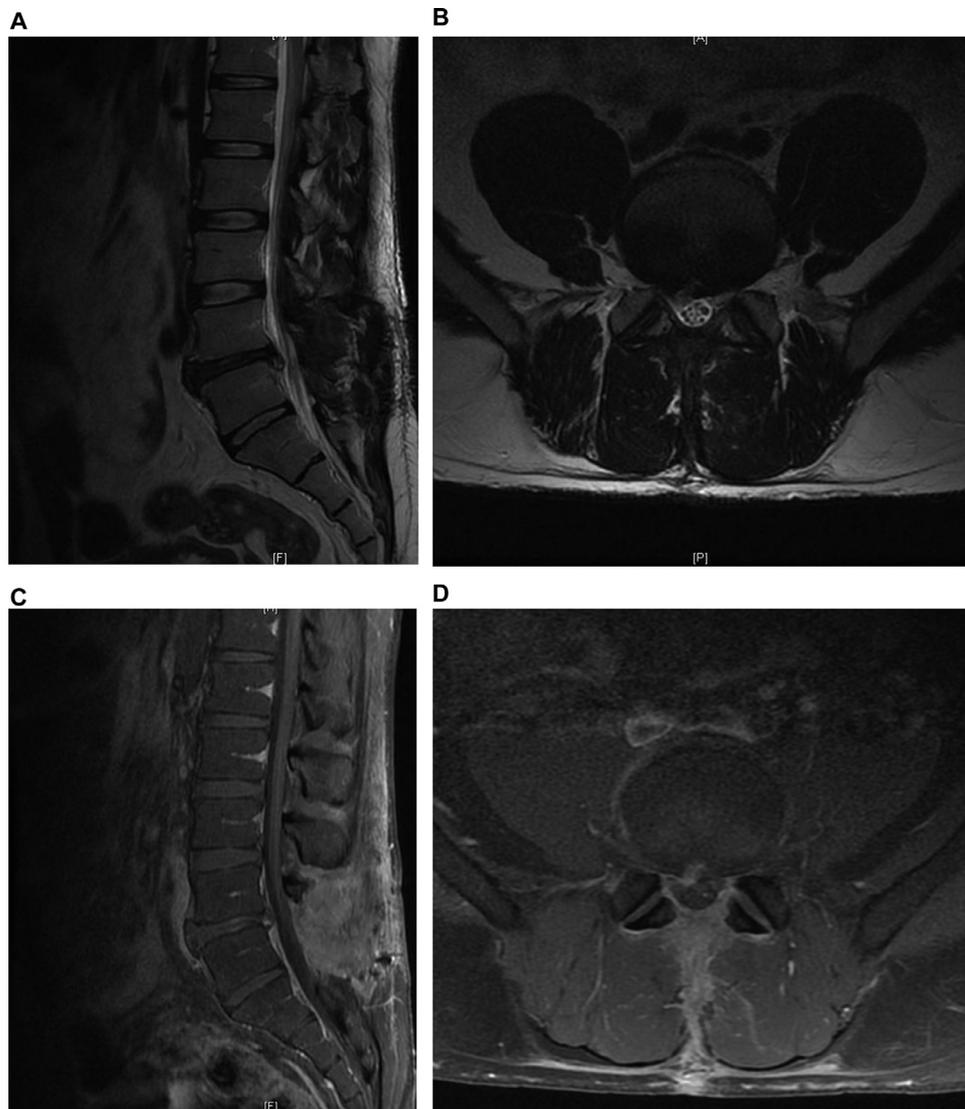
Sagittal (A) and axial (B) T2-weighted MRI images of this patient demonstrating a small recurrent right posterolateral disc herniation and bilateral foraminal stenosis at L4-L5 secondary to facet hypertrophy. Sagittal (C) and axial (D) T1-weighted post-gadolinium images demonstrate significant epidural fibrosis, small posterolateral recurrence within the enhancing region as well as evidence of previous discectomy at this level.
